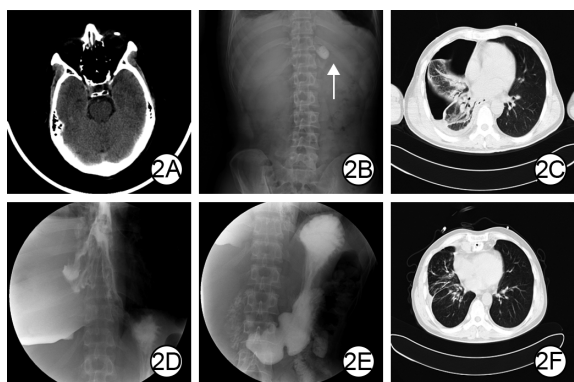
例 2 眼内异物和消化道异物烧冲复合伤患者的检查及治疗情况。2A. 入院 8 h, 颅脑 CT 检查示左眶下异物; 2B. 入院 8 h, 计算机 X 线摄影检查示食道下段异物(白色箭头); 2C. 入院 8 h, 胸部 CT 检查示右下肺不张、液气胸、右胸廓塌陷; 2D. 入院 4 d, 钡餐全消化道造影检查示食道下段、胃底、贲门黏膜纹紊乱、扭曲, 食道右侧胸腔瘘形成; 2E. 入院 5 d, 行食道异物取出, 结肠食道吻合手术后; 2F. 入院 12 d, CT 示右肺复张及条索影
